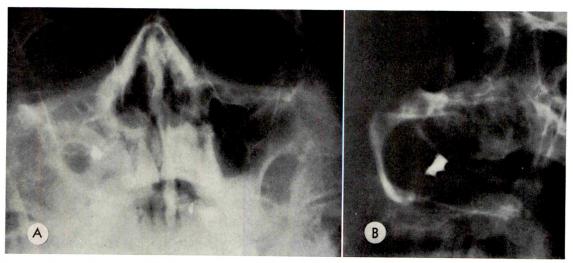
Case 1. (A and B) Roentgenograms of paranasal sinuses showing radiopaque material centrally situated in a clouded right maxillary sinus. Note metallic homogeneous density, polyhedral in shape and irregular in contour.
